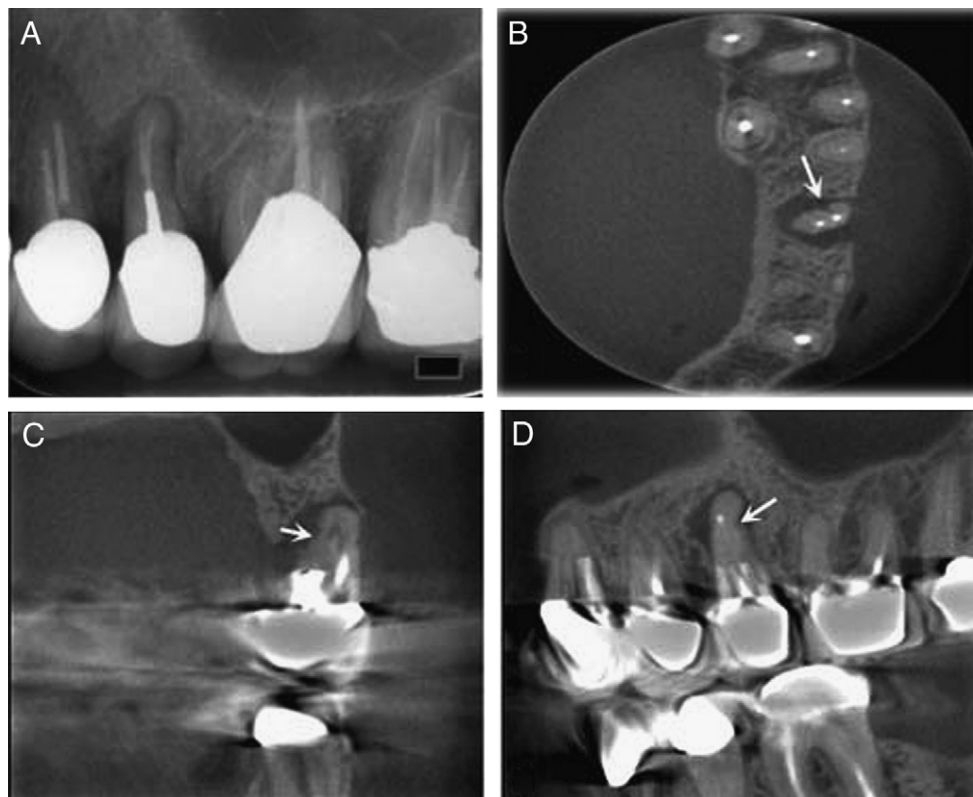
(A) Periapical radiograph of suspected tooth with VRF. (B) Axial CBCT view showing a fracture line running mesiodistally. (C) Coronal view. (D) Sagittal view.
